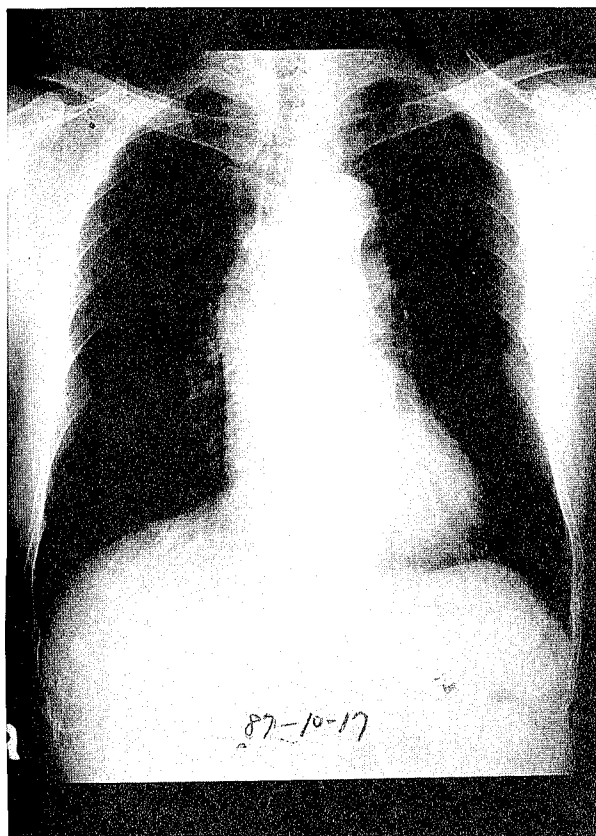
Chest X-ray shows no abnormalities at the time of angiosarcoma of the scalp onset
